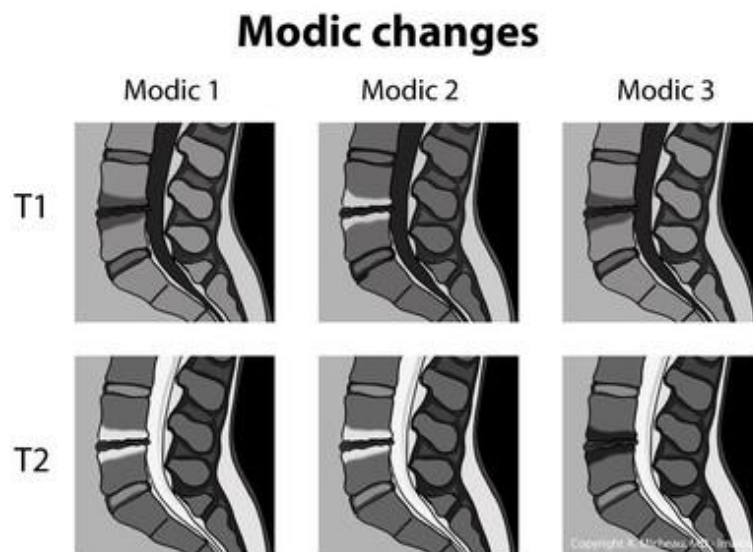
T1 and T2 MRI appearance of each type of Modic changes
